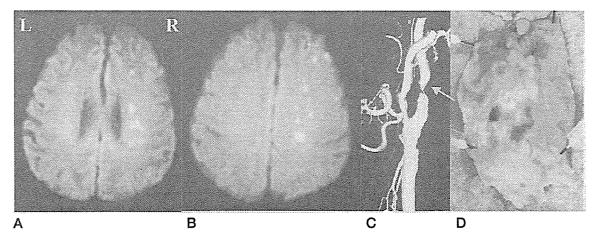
67歳 男性の入院時 stroke MRI
